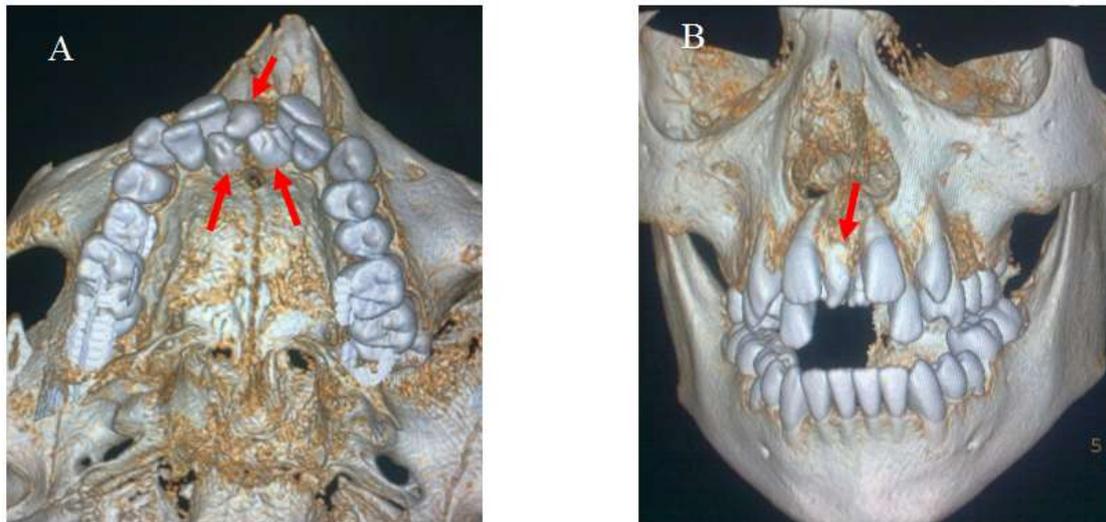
Dental 3D Software CT with multiplanner reconstruction of premaxilla demonstrating a multiple superior impacted supernumerary teeth (red arrows) for the same patient aged 12 year shows the malocclusion, crowding, delay eruption and diastema, (A). Occlusal view .Three multiple superior impacted supernumerary teeth in premaxilla, one conical shape, Type III (labially positioned), causing diastema of upper centrals incisors, right one supplemental shape, the left one Tuberculate shape ,both are Type II (palatally positioned) causing malocclusion, crowding and delay eruption. All are $3 \leq$ number presented. (B) Frontal view of skull and maxilla shows the diastema of upper impacted centrals incisors caused by conical superior impacted supernumerary teeth (red arrows).
